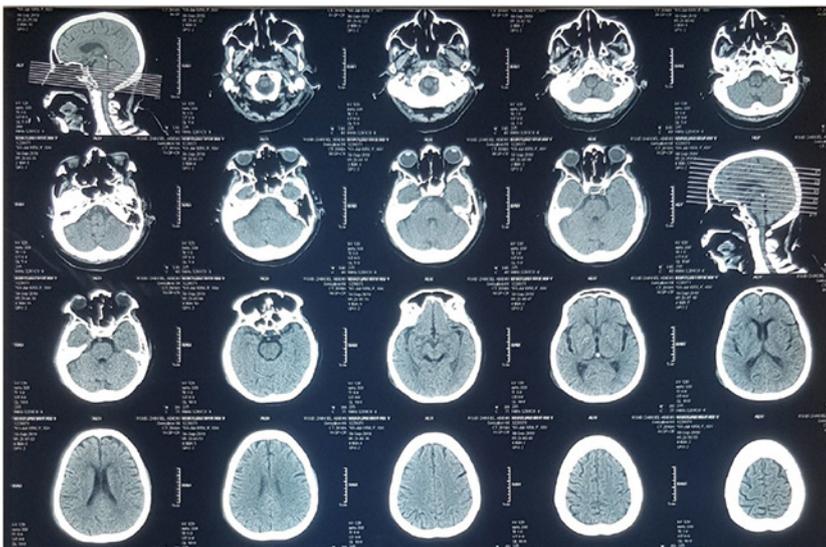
Head CT-scan showed oedema cerebri
